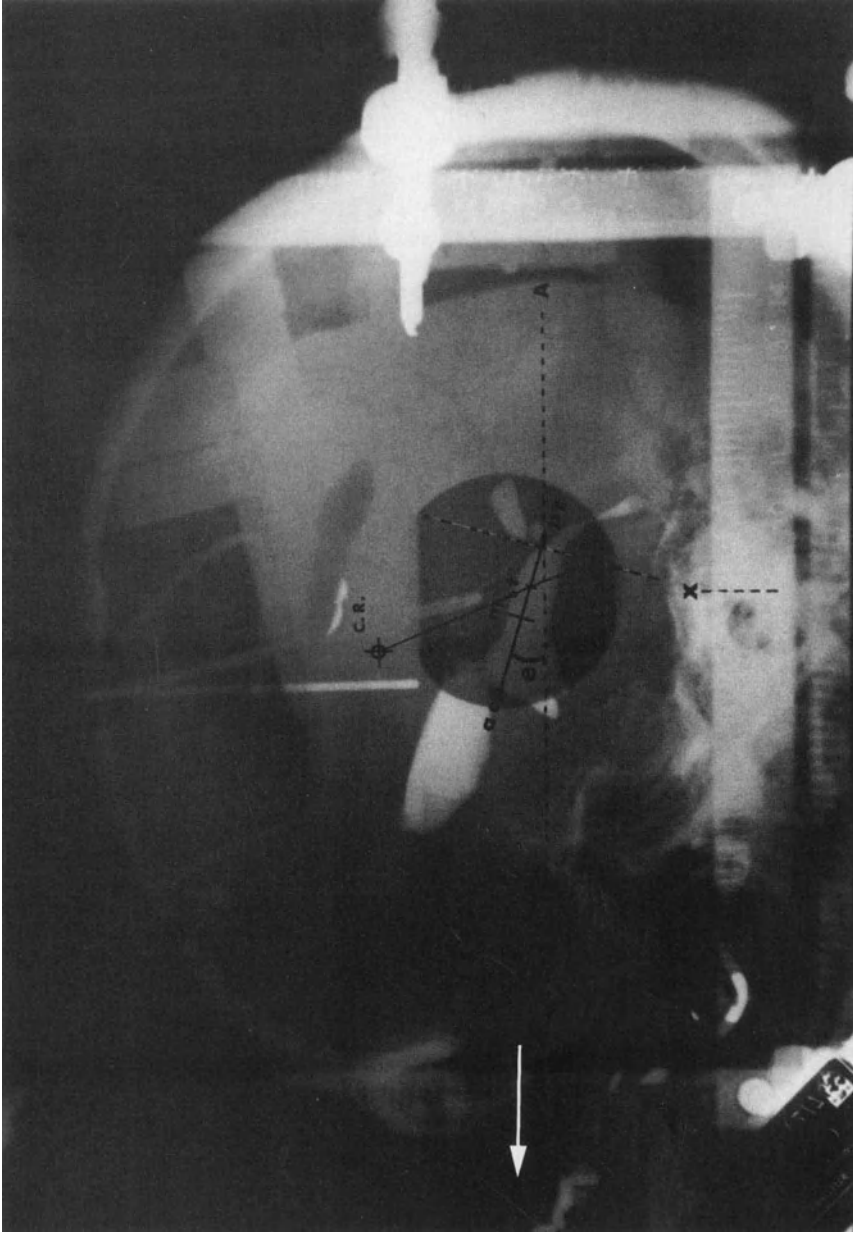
A lateral contrast encephalogram with a styllet in the frontal horn of the lateral ventricle. C.R. is the incidence point of the central roentgen ray beam on the roentgenogram. The radius from C.R. (*arrow*) is constructed to the target (T) on the anterior commissure-posterior commissure line (Leksell method [13]). The point along this radius above T is the corrected target position for magnification and distortion. X and Y (*white arrow*) are coordinates for this corrected target. Line A is the horizontal plane of the frame. Angle e represents the skew angle (Leksell stereotactic frame [4, 14]).
